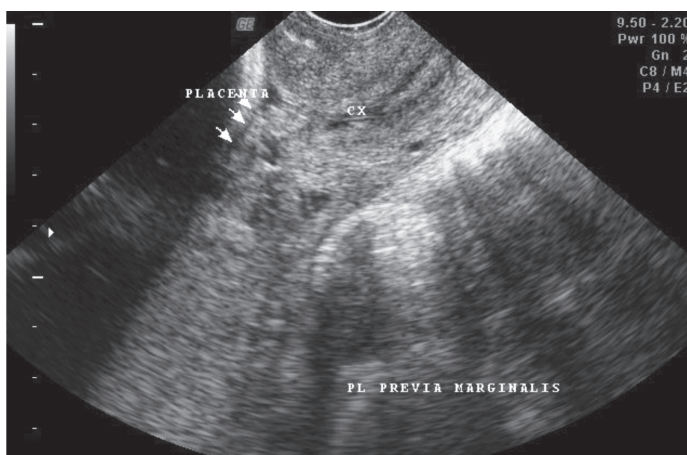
Ultrasound at 36 weeks age of gestation: Placenta posterolateral grade III with hydropic changes, consider placenta previa marginalis.
